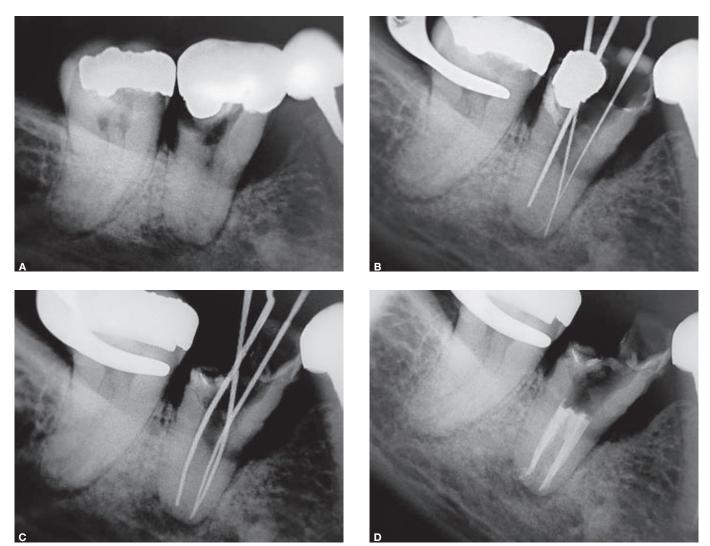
A) Preoperative radiograph. B) Odontometry radiograph. C) After instrumentation. D) Final radiograph.
